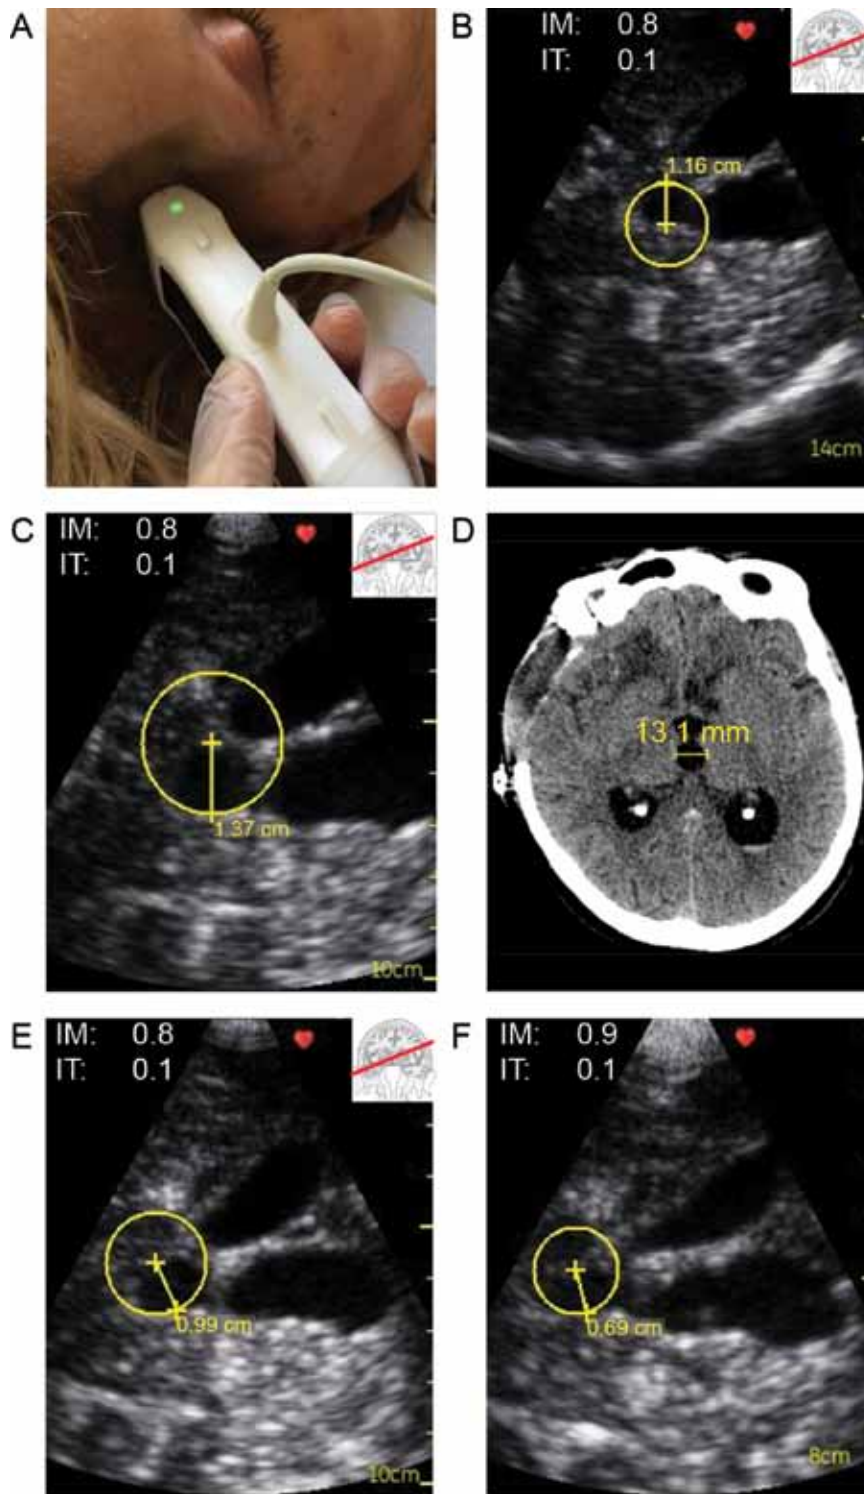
(A) Transcranial sonography (TCS) using a hand-held pocket ultrasound device (GE Vingmed Ultrasound AS, Horten, Norway) on a patient with craniectomy. (B) Prior to external ventricular drain (EVD) clamping, TCS showed a measurement of the 3rd ventricle at approximately 1.16cm. (C) On the third day, TCS showed a dilated 3rd ventricle measuring 1.37cm. (D) Computed tomography scan confirmed those sonographic findings showing a dilated 3rd ventricle measuring 1.31 cm (13.1mm). (E) One day after reopening the EVD, the size of the 3rd ventricle decreased to 0.99cm as measured by TCS. (F) The following day, it went down to 0.69 cm.
